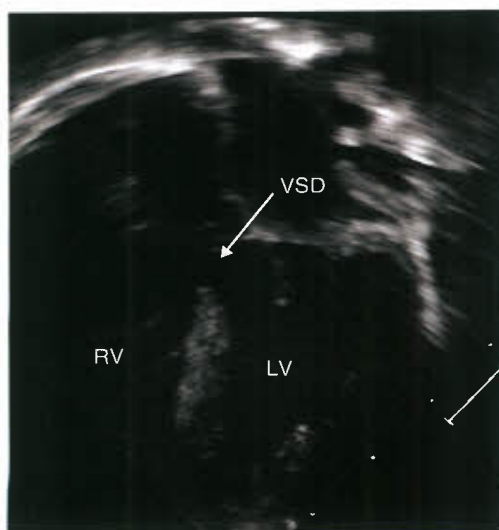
Apical four-chamber view at the level of the tricuspid and mitral valves demonstrating a moderate-sized isolated inlet VSD.
